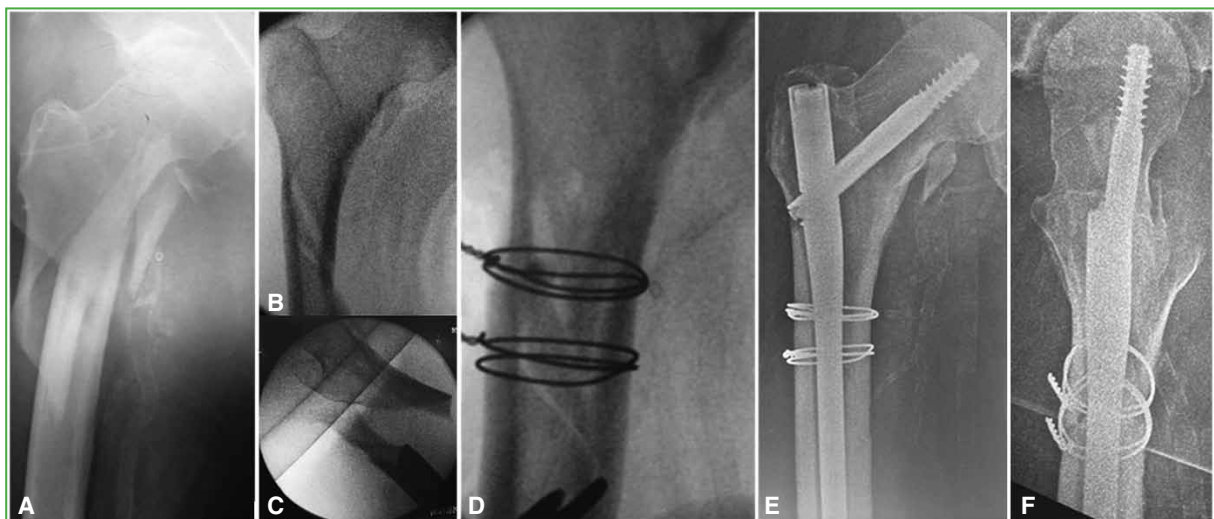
A. Anteroposterior radiograph of the right proximal femur. A 3A subtrochanteric fracture is observed. Intraoperative radioscopy. B. Anteroposterior view showing acceptable alignment. C. With the same reduction of image A, but in the lateral view, where a significant misalignment is observed. D. Reduction with cerclage wire. E and F. Anteroposterior and lateral radiographs of the right proximal femur in the postoperative control, where consolidation can be observed.
